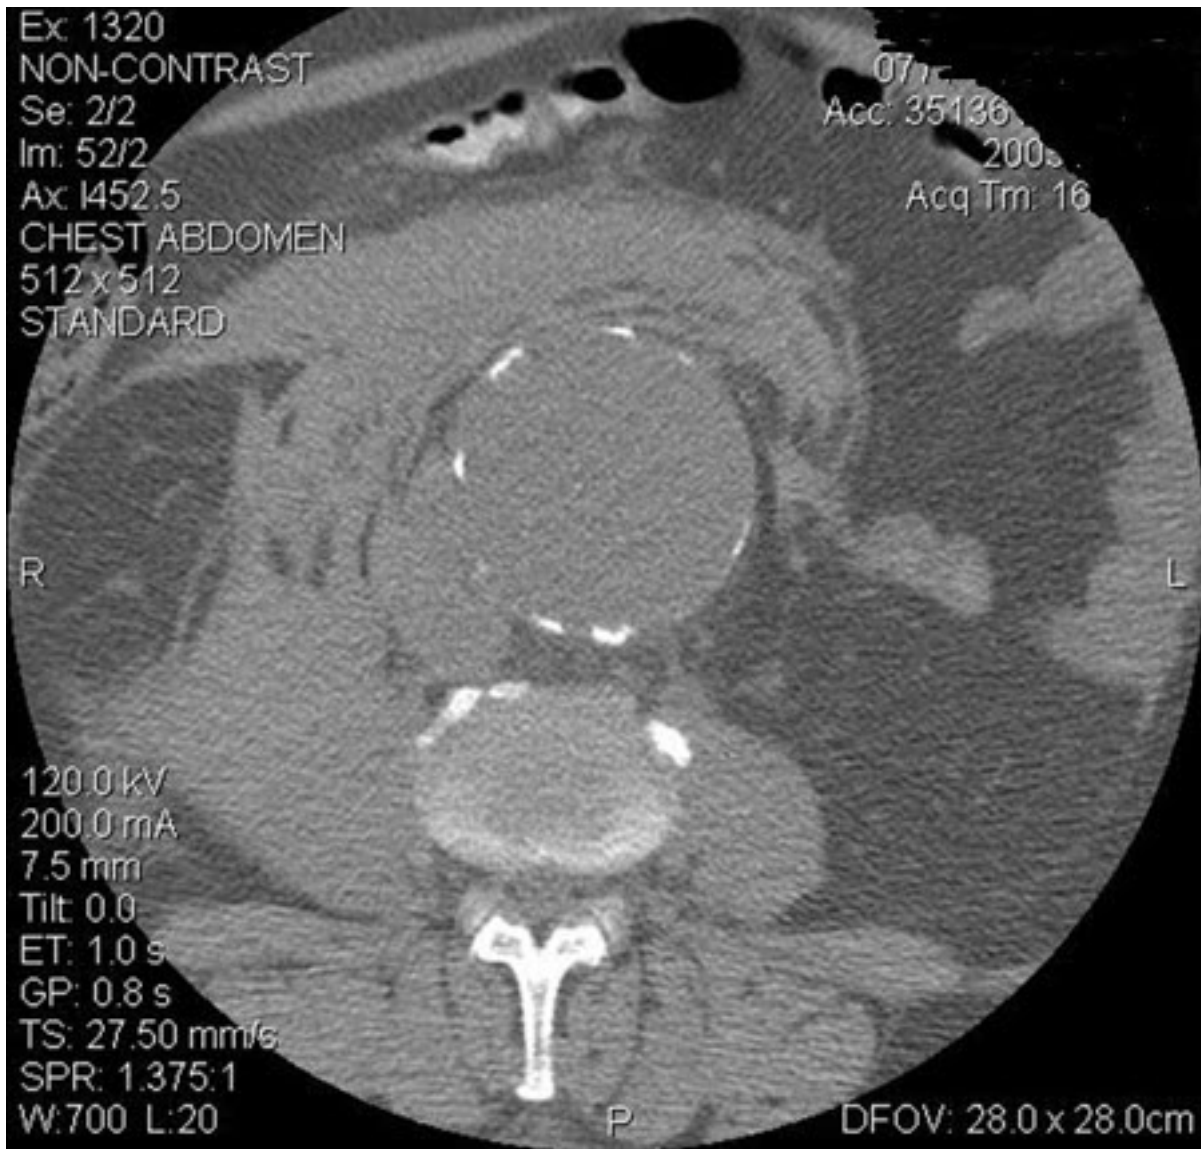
Abdominal aortic aneurysm: CT scan of a ruptured abdominal aortic aneurysm
